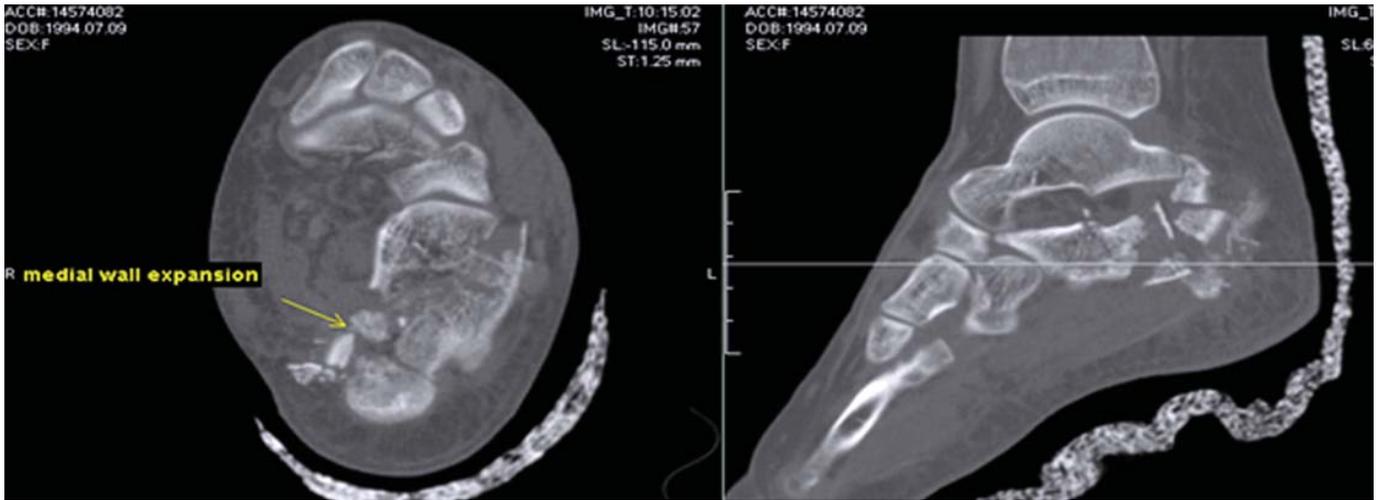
Preoperative CT
